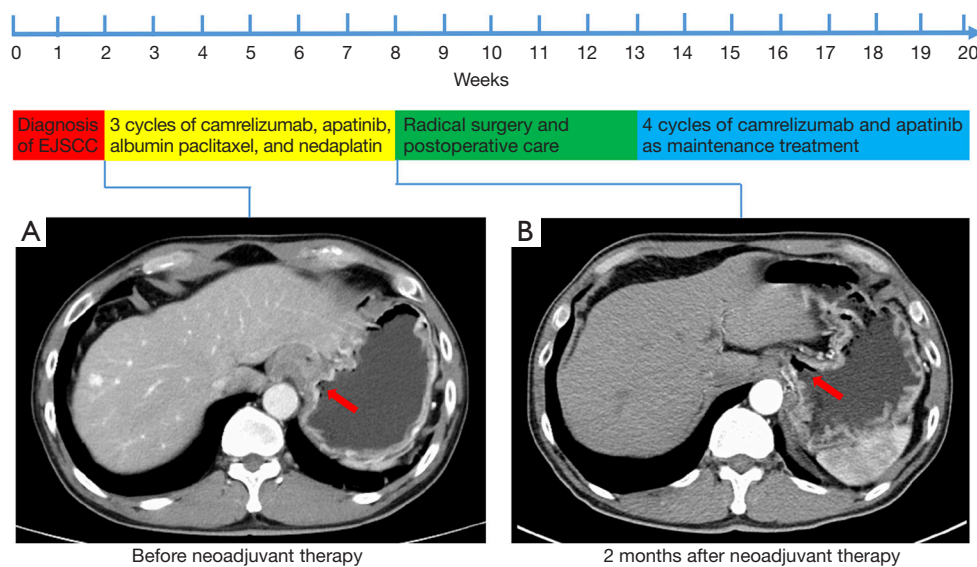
The timeline of the whole treatment and the CT scans. (A) An initial enhanced CT scan found a locally advanced, potentially unresectable EGJ mass (red arrow). (B) The mass on the second CT scan was significantly shrunk (red arrow). EJSCC, esophagogastric junctional squamous cell carcinoma; CT, computed tomography; EGJ, esophagogastric junctional.
